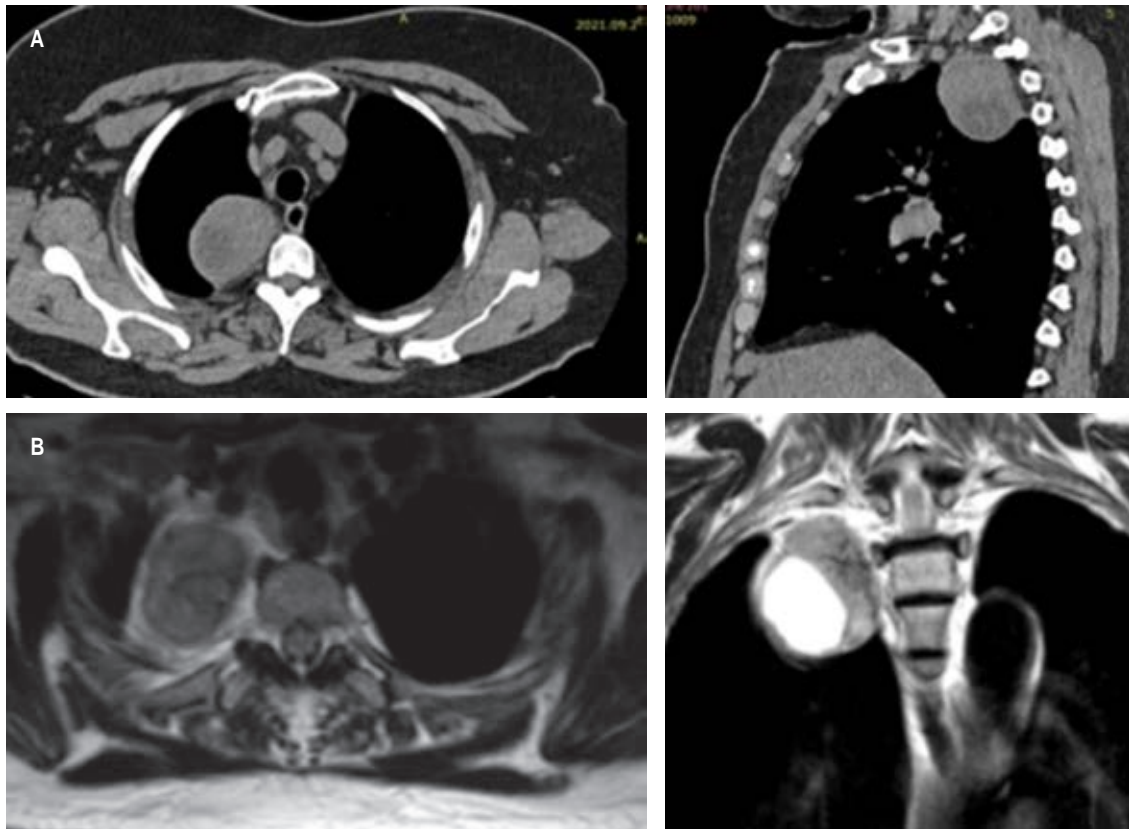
A) Simple computed tomography in axial and sagittal slices showing the tumor in the posterior mediastinum, heterogeneous and with defined borders. B) Axial and coronal T2-weighted magnetic resonance images showing the tumor in close communication with the paravertebral sulcus.
